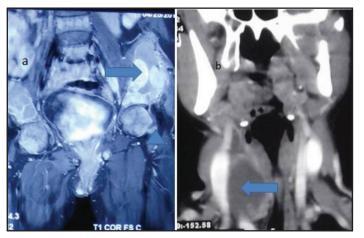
MRI pelvis showing the bilateral fracture neck of femur and enhancing cystic cavity in both iliac bone (a) and CT scan (b) showing the eccentric, heterogeneous mass from posterior right lobe of thyroid abutting to trachea and displacing carotid artery and right internal jugular vein.
